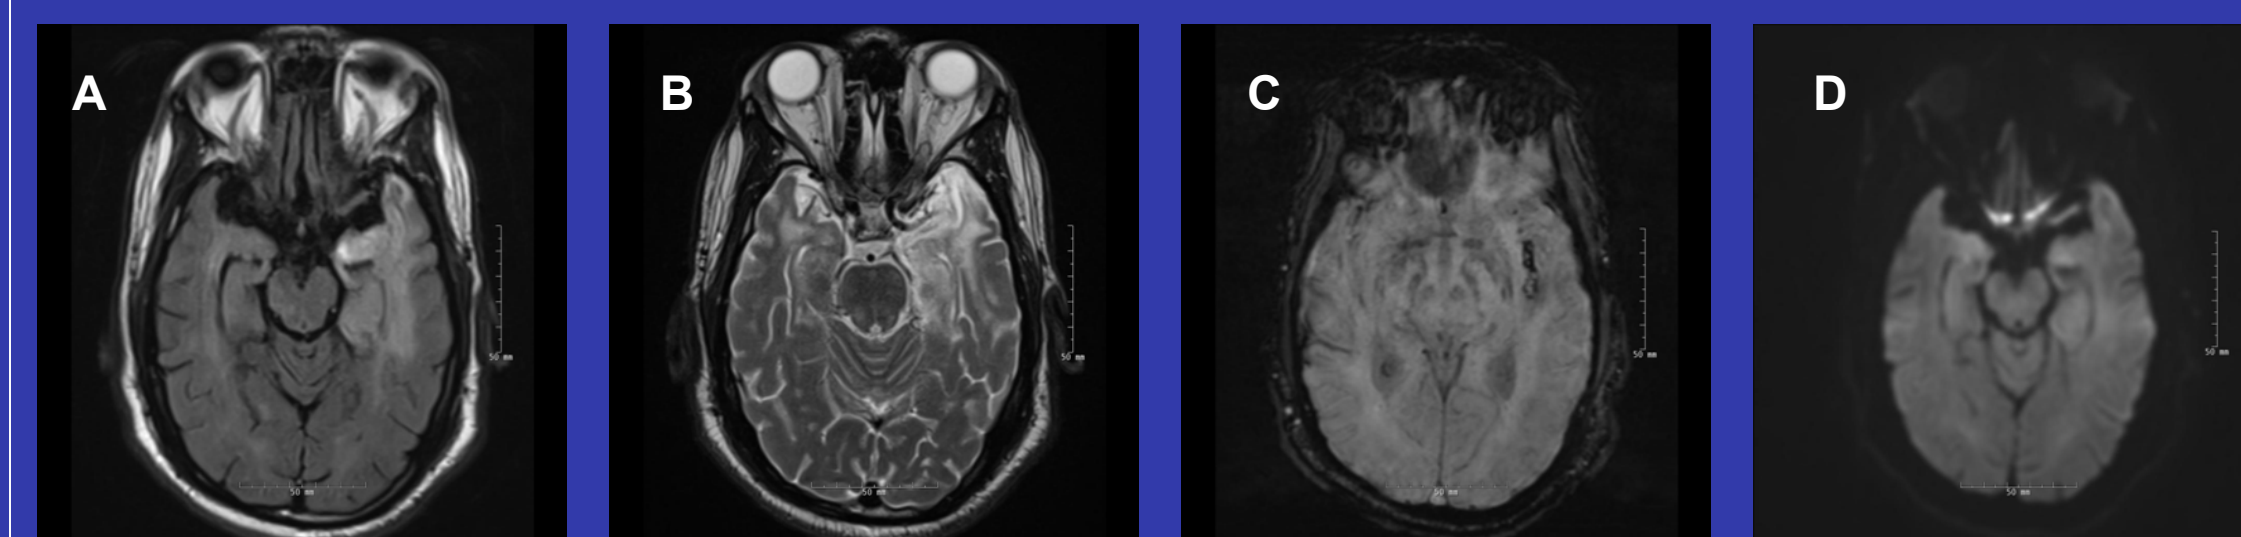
MRI Brain during HSE, after 2 weeks of IV acyclovir. Interval development of more confluent T2/FLAIR hyperintensity (A-B) with associated petechial blood products in the left medial temporal lobe and insula on SWI images (C). Interval resolution of restricted diffusion on DWI sequences (D).
